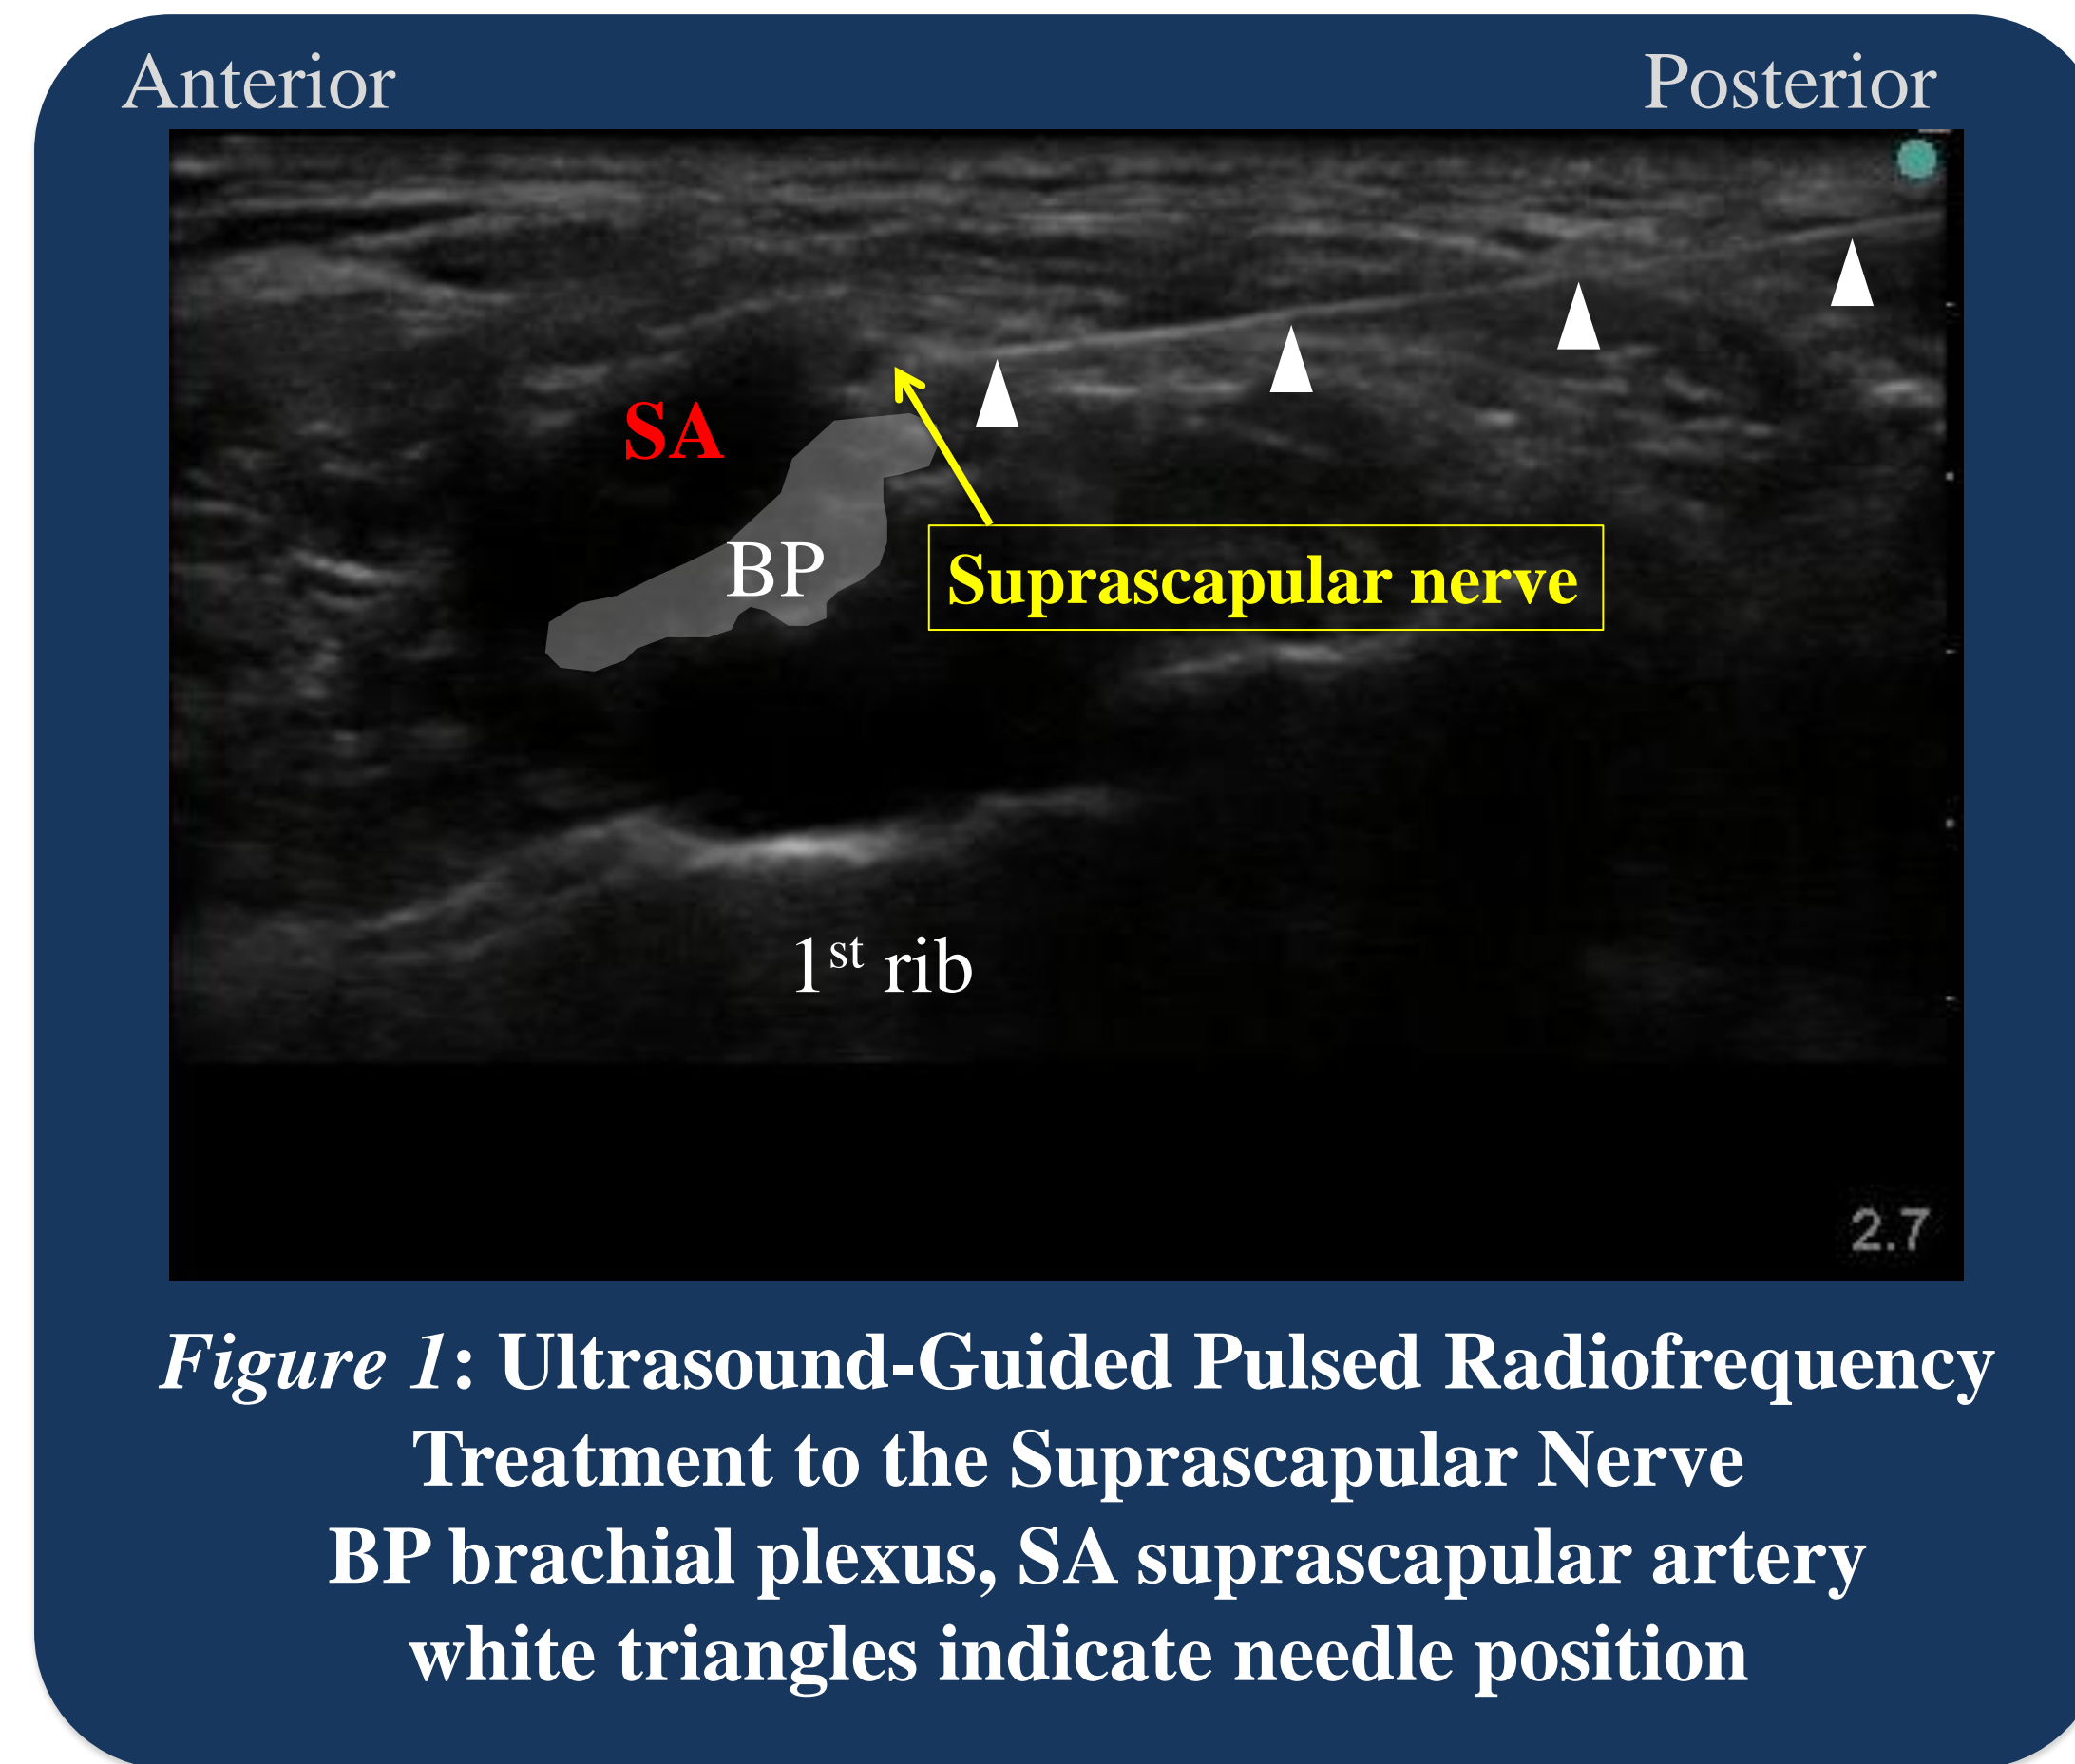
Ultrasound-Guided Pulsed Radiofrequency Treatment to the Suprascapular Nerve
